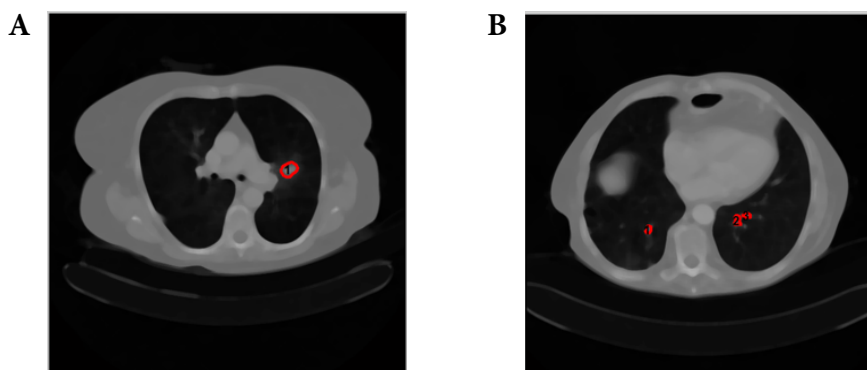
Result after classification of the lung region with a red outline (cancerous). (A) The preprocessed lung computed tomography image before region-of-interest extraction. (B) The region-of-interest extracted using mask seeded region growing, highlighting the suspicious tumor area.
